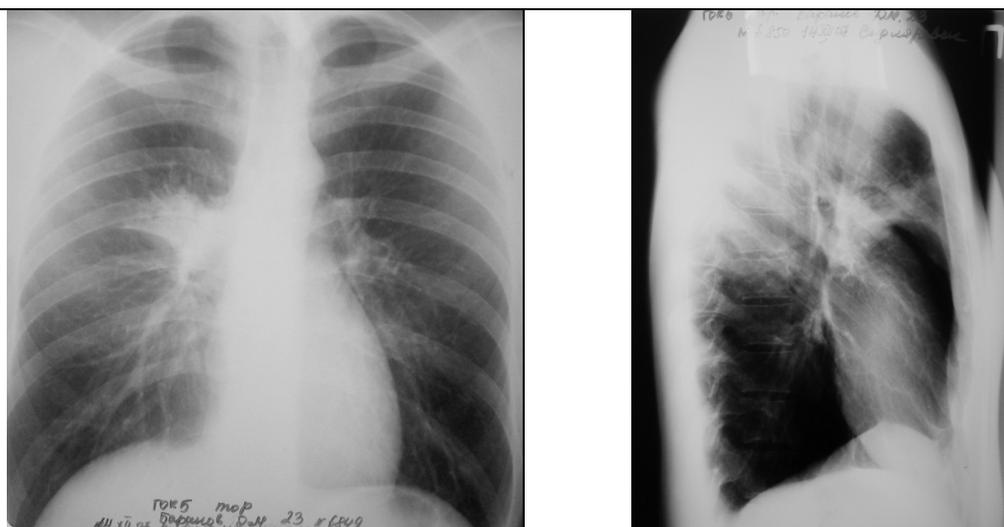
Survey radiographs of the 23-year-old patient's thorax in frontal and right lateral projections. The limited shadow in the forward (III) segment of the upper lobe of the right lung. Shadow has average intensity in the medial part and small intensity on the peripheries, its contours are indistinct, except for the bottom border adjoining the interlobe fissura. The lung root on the right is expanded. Acute right pneumonia with affection of the anterior segment of the upper lobe of the right lung by analogy with periscissuritis.
